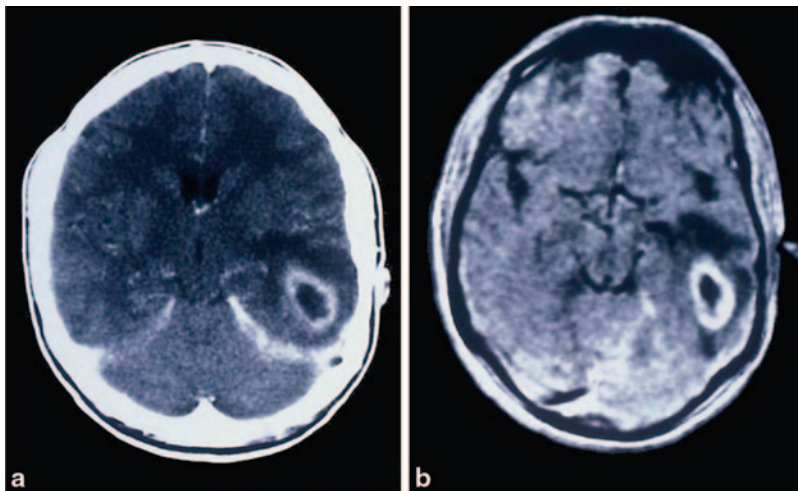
Brain abscess shown as ring-enhancing lesion by CT scan (a) and MRI scan (b) (Courtesy of Dr. Blaine Hart)
